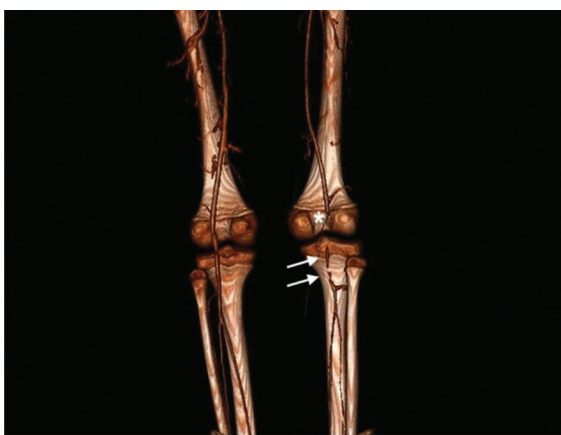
Inferior limbs computed tomography angiography showing the right popliteal artery occlusion (*), with partial downstream re-permeabilization with some filling defects (arrows).
